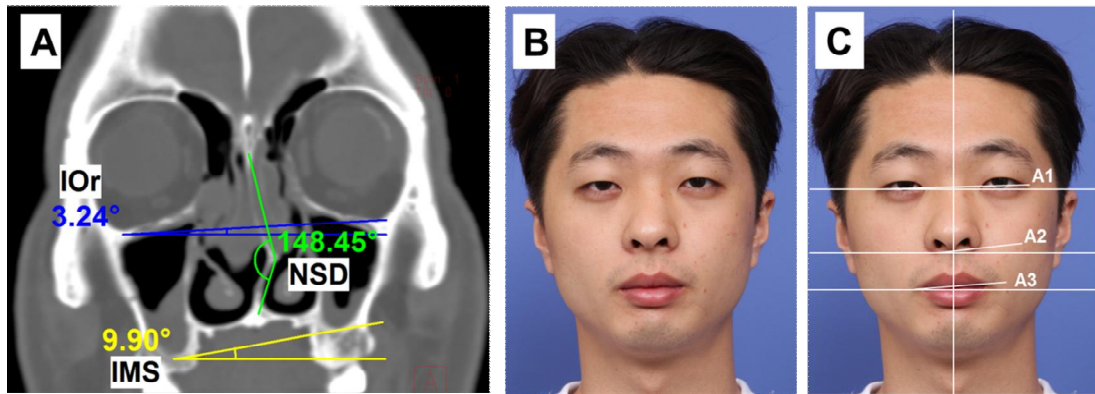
Measurement of the Nasofacial Structures. A, Measurement on the nasofacial skeleton structures shown on the OMU CT image. The most inferior point of the orbit (IOr) and the most inferior point of the maxillary sinus (IMS) were marked in both sides. In a similar fashion along with the NFT measurement, an angle between the two lines was measured. To measure the NSD angle, the most protruded point of the bony nasal septum was marked, and the angle formed by the lines from the marked point to the center of the cribriform plate and maxillary crest were measured. B, To evaluate the perceived facial asymmetry, the photograph of a frontal view of each patient's face was stared for 10 seconds. In patients with asymmetrical face, a horizontal level difference and volumetric asymmetry were determined. C, To investigate the quantitative asymmetry on each facial subunit, the lateral canthus, the most inferior point of the alar base, and lateral angular margin was marked on both sides. In parallel with the NFT angle measurement, a horizontal line was drawn on one point, and a line connecting both landmarks were drawn. The angle between two lines were measured, and was defined as A1, A2, and A3, each representing the upper face, middle face, and lower face, respectively.
